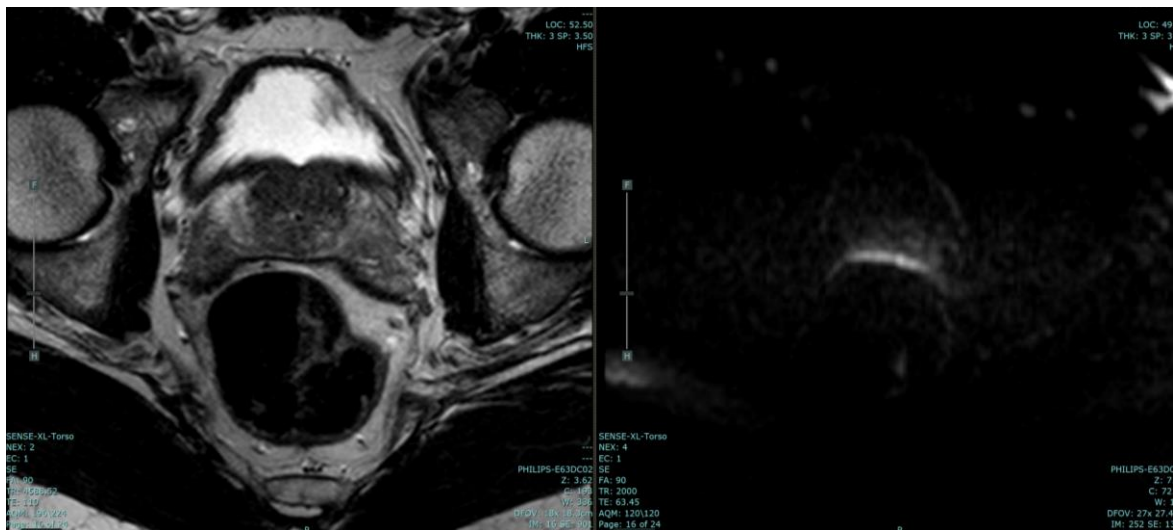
Commonest artifact encountered in DWI sequence- magnetic field
